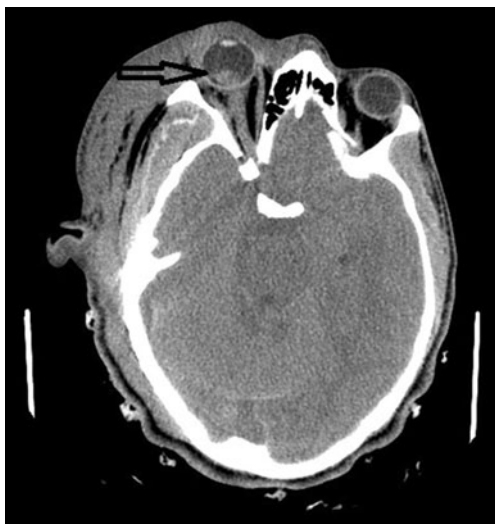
Axial noncontrast CT image demonstrates worsening intraocular hemorrhage in conjunction with partially visualized worsening global cerebral edema and subarachnoid and subdural hemorrhage
